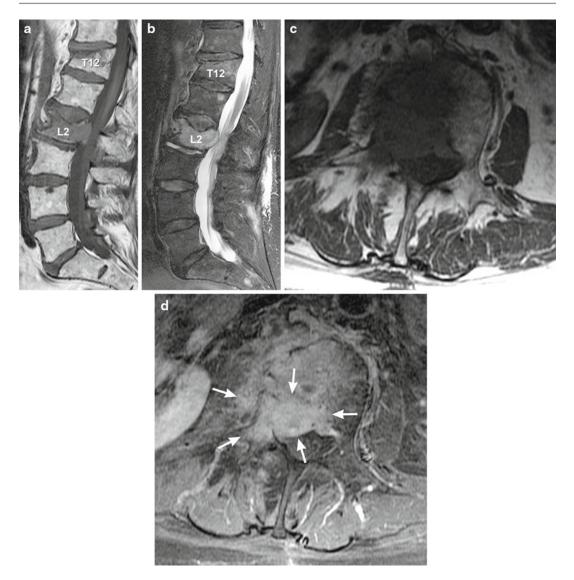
Benign and malignant fractures. A 68-year-old woman presents with new low back pain and right groin and medial thigh pain. Sagittal T1 (a)-weighted and fat-saturated T2 (b)-weighted MRI images show a benign-appearing compression of the superior end plate of T12. Note that marrow signal change is restricted to the immediate sub-end-plate marrow. There is also a malignant, pathologic compression fracture of L2, and here the signal
